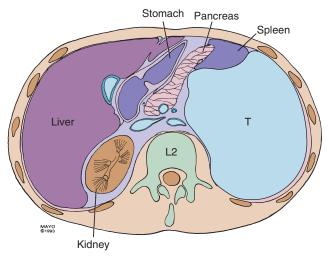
Appearance of left upper quadrant mass on CT scan. *T*, Tumor. *Courtesy the Mayo Foundation.*
